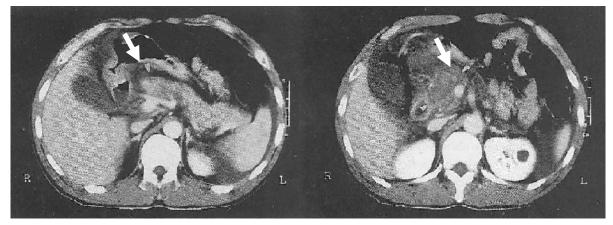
Enhanced CT revealed a laceration of pancreatic head (left, white arrow) and a hematoma near pancreas head (right, white arrow).
